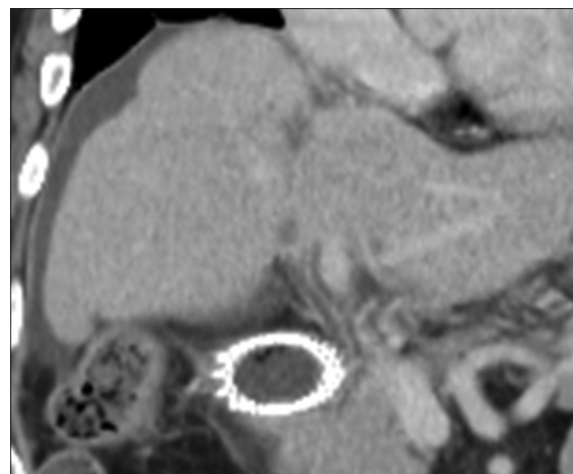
Computed tomography on day 123 after first nivolumab or 90 days after immune-related pneumonitis showed a nearly complete response without any further administration of anticancer treatment
